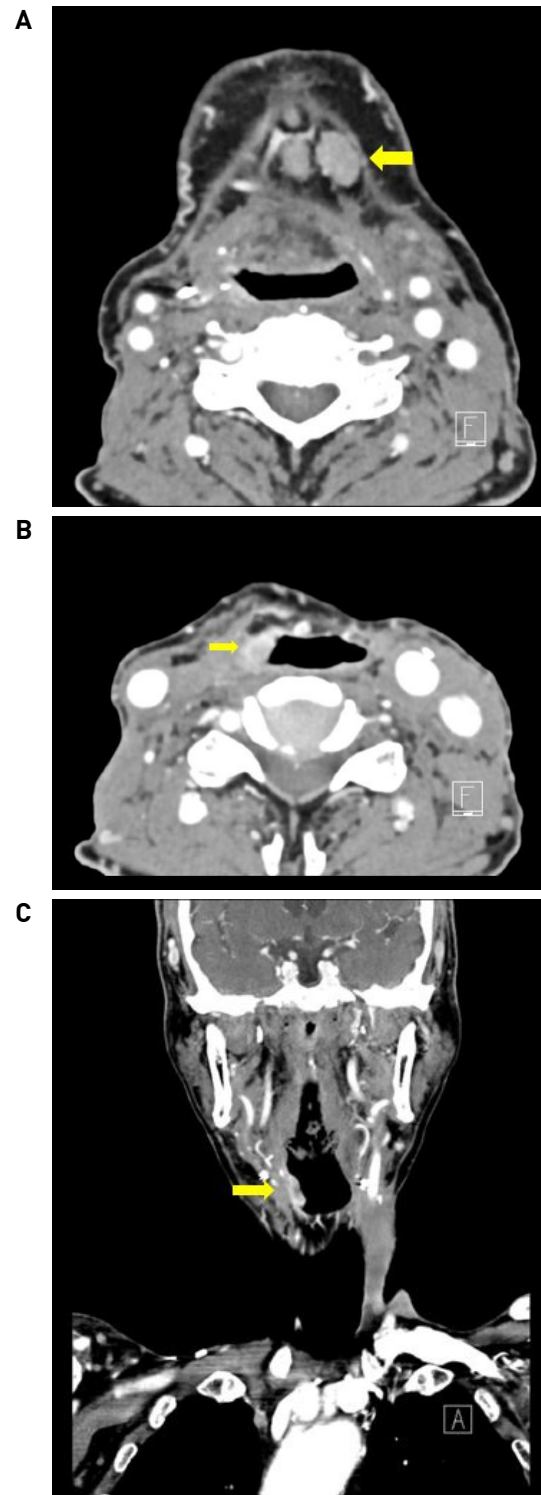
Laryngeal CT taken before the surgery shows enlarged lymph node in left level Ia (A). Enhancing lesion is found from tongue base to pharyngoesophageal junction, along the lateral neopharyngeal wall (B, C).
